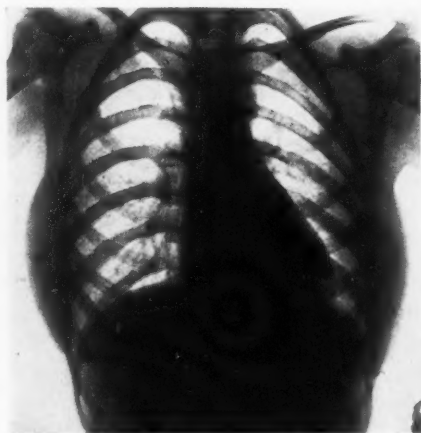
Roentgenogram in the anterior-posterior view.
